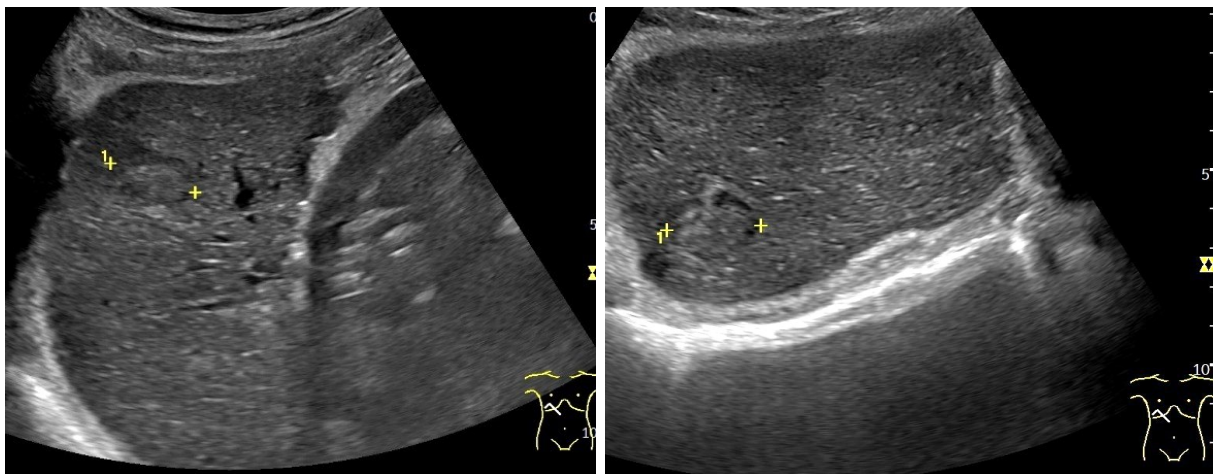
A-B. B-mode ultrasound images showing a predominantly heterogenous focal lesion in the right hepatic lobe, with a hypoechoic halo, findings that raise suspicion for hepatocellular carcinoma in the context of liver cirrhosis.
